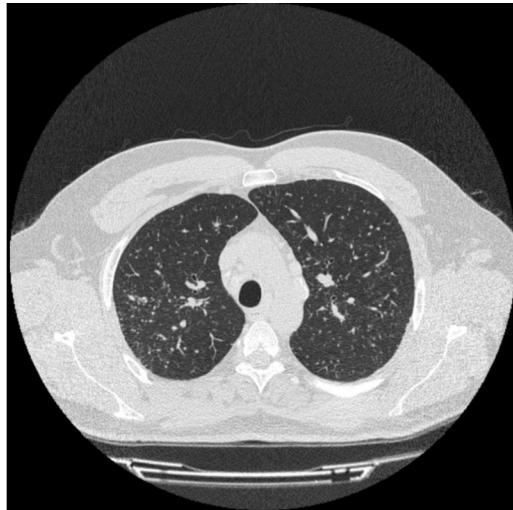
Chest CT. Diffuse micronodular pattern in both lung fields.
